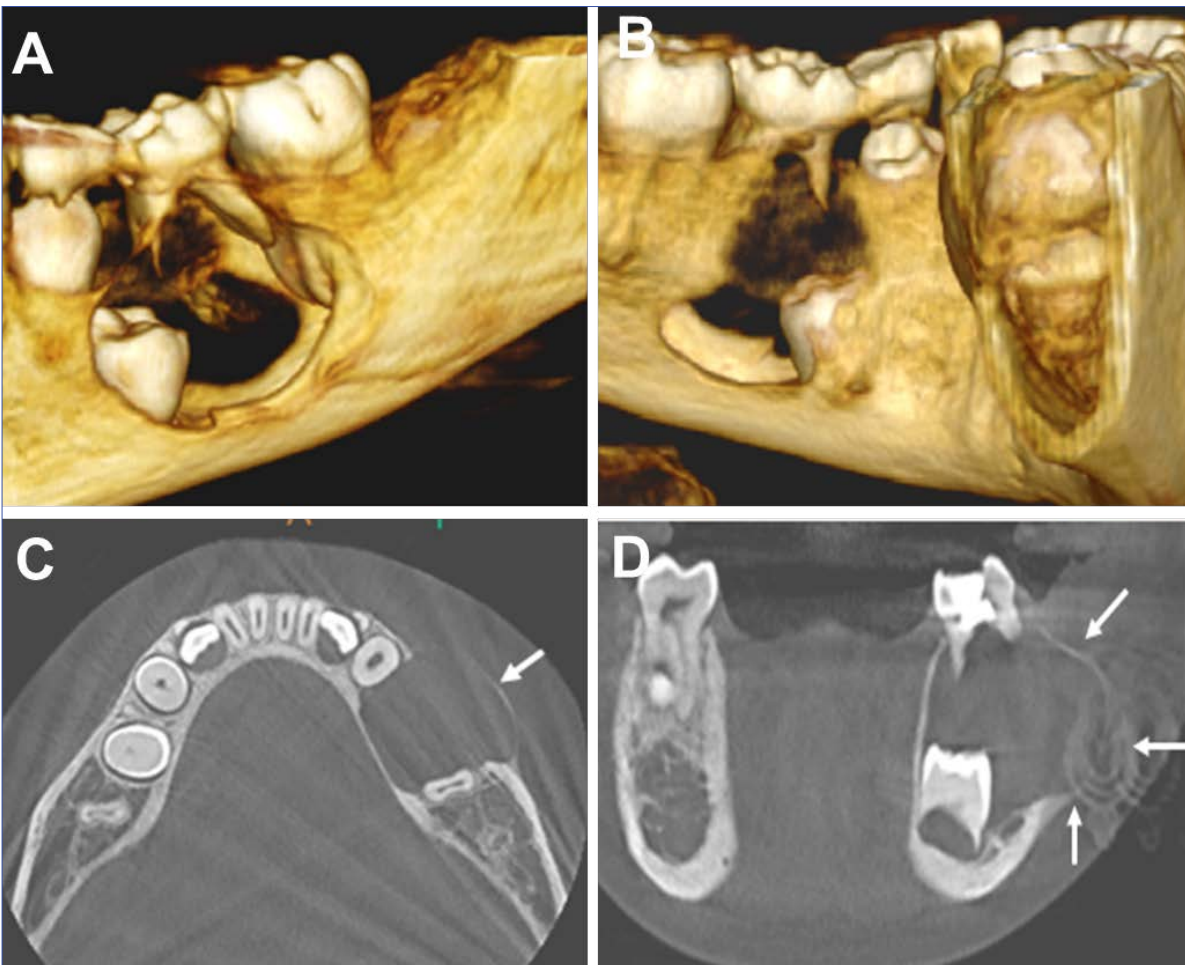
CBCT images (3D reconstruction) demonstrating massive destruction of the buccal cortex (A) and lingual cortex (B). CBCT axial view (C) and coronal view (D) demonstrating expansion of the buccal cortex and thinning of the lingual cortex.
